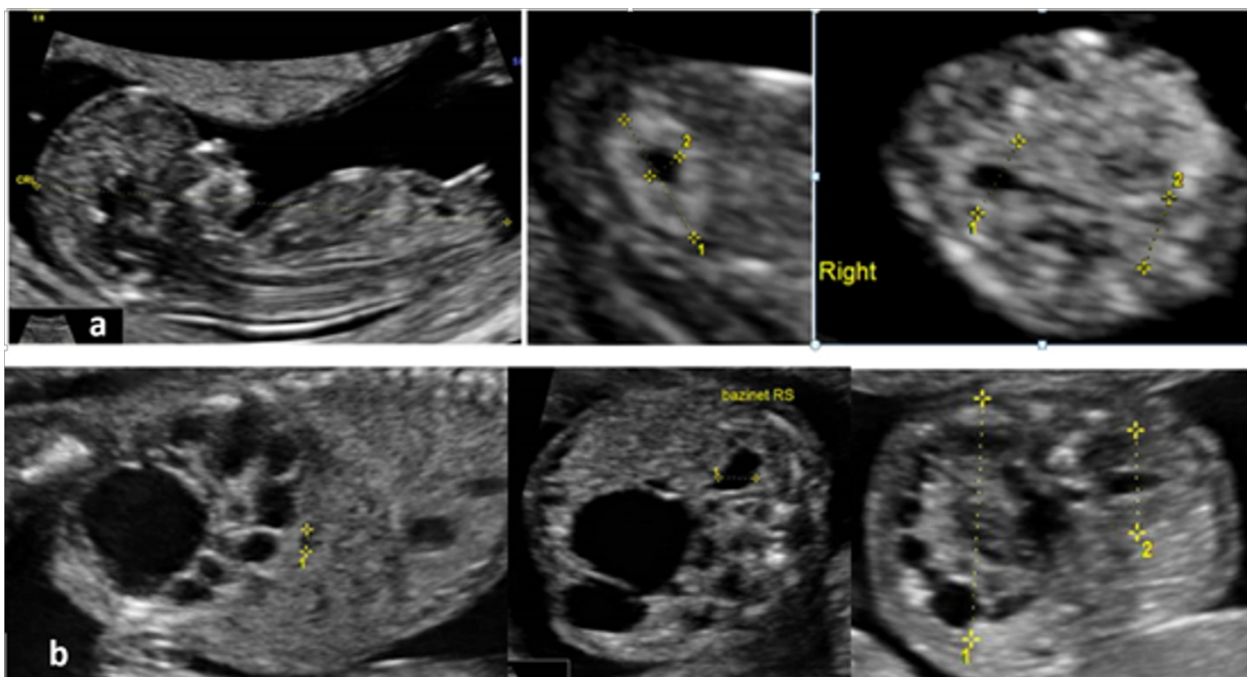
Case 1, ultrasound features at 11+3 gestational weeks (first row) and at 16+2 gestational weeks (second row)
